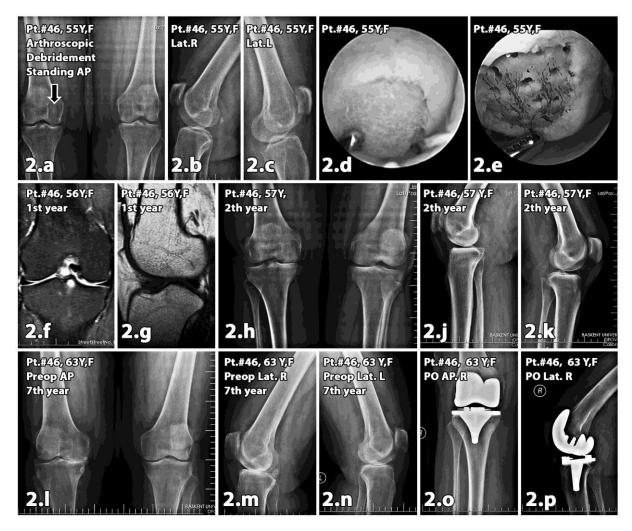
Pt.#46, This 55 years-old woman had Kellgren-Lawrence Classification (KLC) grade-2 degeneration at first admission. (a) Arrow is pointing the cartilage defect on the femoral condyl in preoperative Rosenberg AP x-rays of both knees prior to arthroscopic debridement, (b,c) lateral x-rays of both knees, (d) recordings image during arthroscopy after arthroscopic debridement of the cartilage defect, (e) the image after arthroskopic micro-fracture technique, (f-h) Coronal and sagittal MR scans of the right knee at 1st year, (j-l) Standing AP and lateral x-rays of both knees at 3rd year, (m,n) Standing AP and lateral X-rays of both knees at 7th year, (o,p) AP and lateral x-rays following total knee arthroplasty at 7th year.
